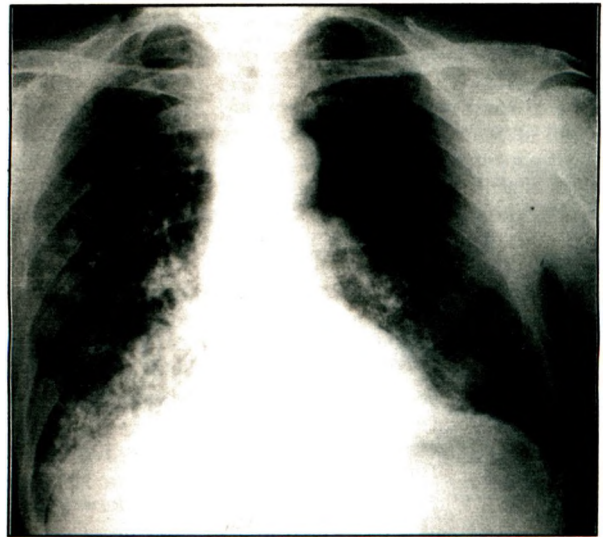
Chest x-ray showing bilateral infiltration 2 years after the aspiration
